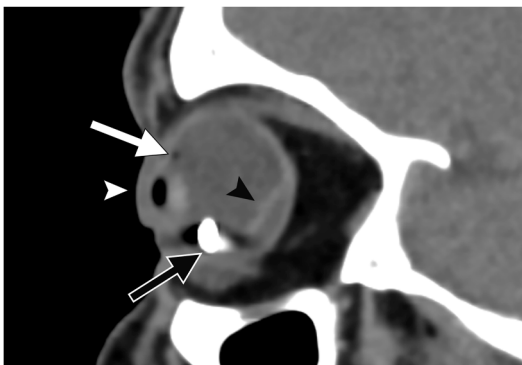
Sagittal right CT orbit showing a hyperattenuating metallic intraocular foreign body (*black arrow*) with beam hardening artifacts. There is intraocular (*white arrow*) and anterior chamber gas (*white arrowhead*) and vitreous hemorrhage (*black arrowhead*). The globe shape appears preserved despite the penetrating foreign body.
